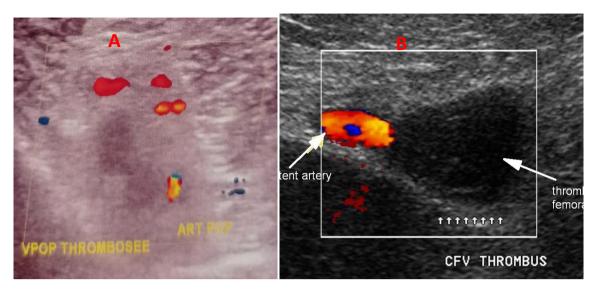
A-Doppler ultrasonography of the right lower limb: showing a deep vein thrombosis (DVT) of the right popliteal vein B-Doppler ultrasonography of the left lower limb: showing a DVT of the left common femoral
